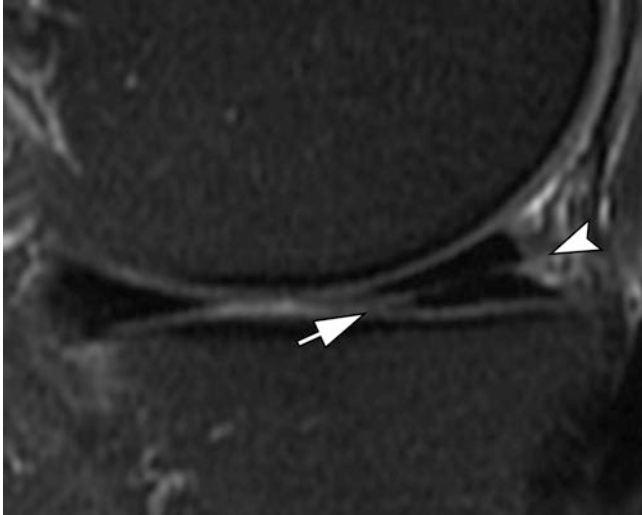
Horizontal tear. Sagittal T2-weighted image of the knee with fat suppression. There is a horizontal tear of the mesial meniscus, extending to the free edge (arrow) and posterior capsular surface (arrowhead)
